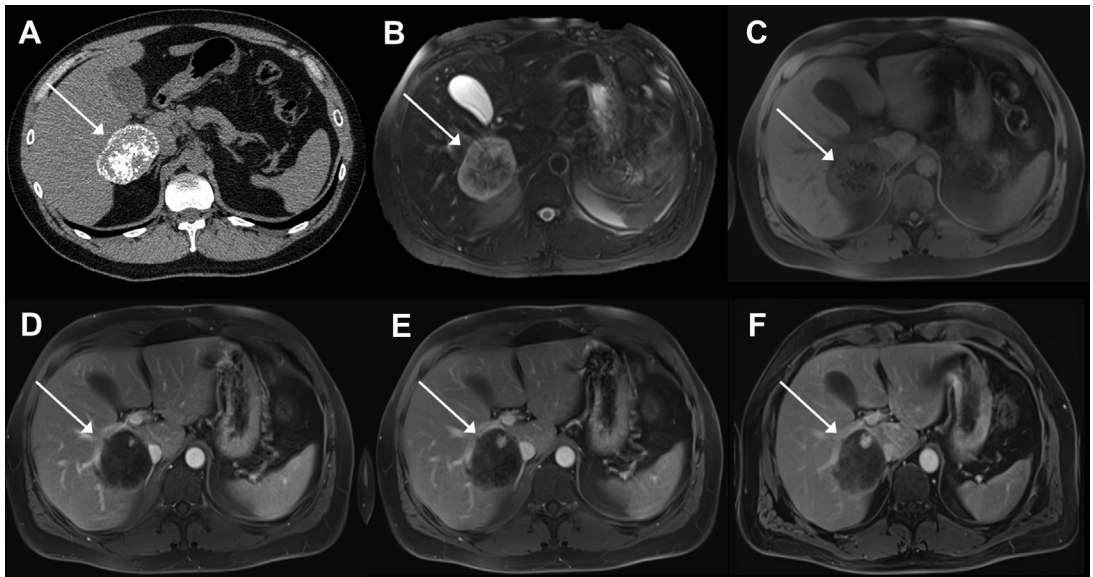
Calcified hemangioma. The enhanced CT scan (A) showed an almost completely calcified lesion. Given the calcification, the lesion showed a heterogeneous signal intensity on fat-saturated T2-weighted imaging (B) and fat-saturated T1-weighted imaging (C). After injection of contrast, the single nodular peripheral discontinuous hyperenhancement (D–F) was consistent with the diagnosis of calcified hemangioma.
